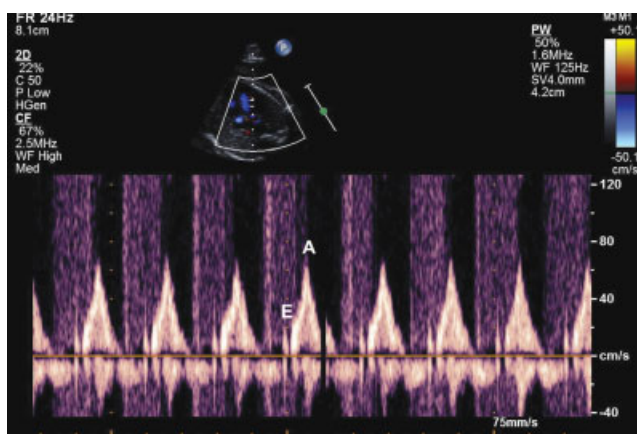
Pulsed Doppler echocardiogram with sample volume located on the color signal behind the left ventricular echogenic intracardiac focus revealing an artifactual spectrum composed of straight vertical bands with a clear outer profile, occurring in middle to late systole and in early diastole. The mitral valve signal shows fusion of early diastolic filling (E) and active atrial contraction (A).
